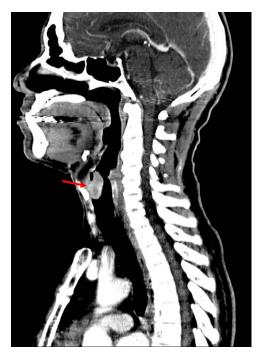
Sagittal CT of the neck demonstrates the 2.5-cm oval-enhancing mass along the true vocal cords with involvement of the anterior commissure, marked by arrow. The lesion does not demonstrate evidence of extralaryngeal spread, cartilage erosion, or paraglottic invasion. CT, computed tomography.
